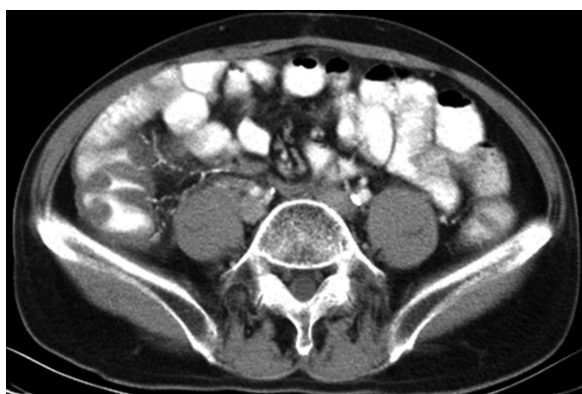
Intravenous contrast enhanced computed tomography with oral contrast ingestion. A 59-year-old male came to emergency room with fever and tenderness at right lower abdomen. The contrast enhanced computed tomography shows wall thickening at the ascending colon and calcifications at straight veins, marginal veins and main branch of mesenteric vein, suggestive of phlebosclerotic colitis.
